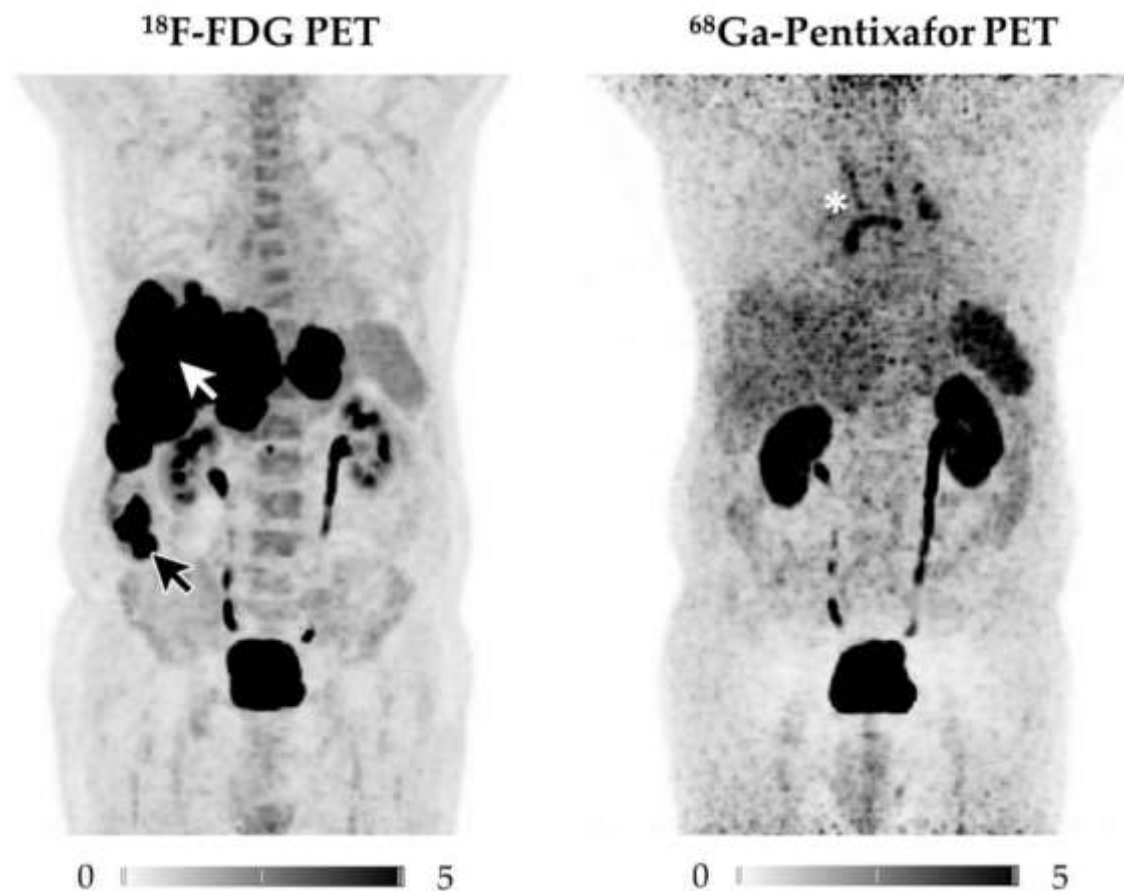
Maximum Intensity Projections (MIP) of the ^{18}F -FDG (left) and ^{68}Ga -Pentixafor. Whereas ^{18}F -FDG depicts the ileal primary (black arrow) as well as multiple liver metastases (white arrow), none of the tumour manifestations are
